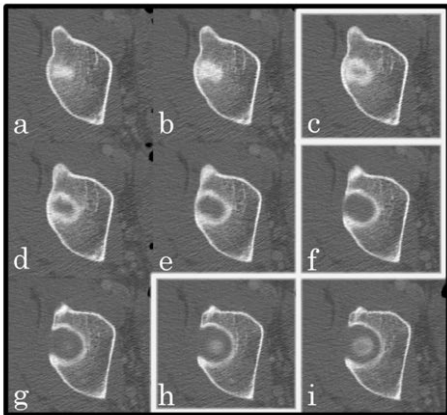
Consecutive axial CT slices through the right acetabulum demonstrates Level 0 (c), Level 1 (f) and Level 2 (h). Dome height (DH) is 3 in this example while head height (HH) is 2. Dome-head difference (DHD) is therefore 1.
